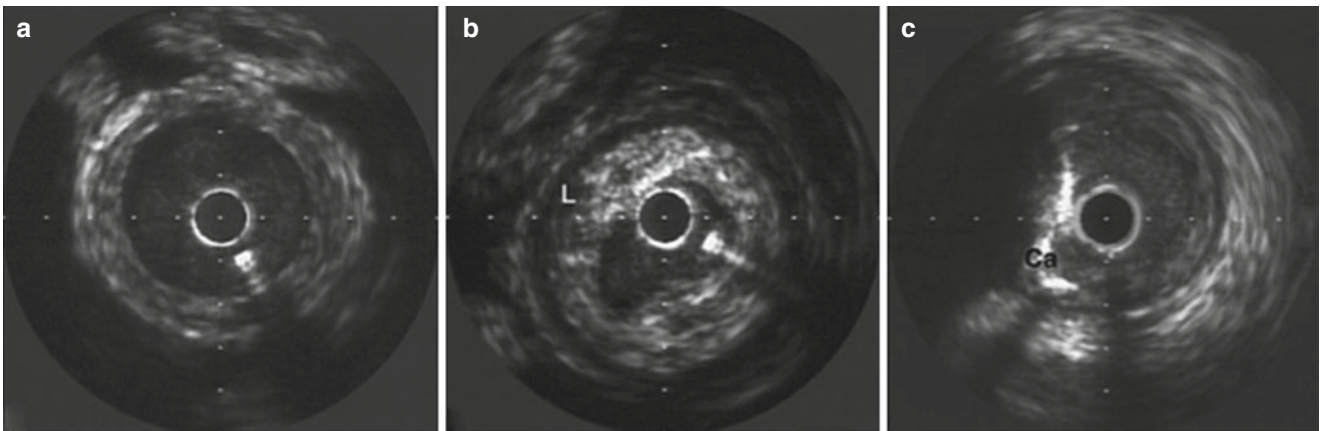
Typical intravascular ultrasound appearances of saphenous (a) vein graft neo-intimal hyperplasia. (b) L–lipid rich plaque. (c) Ca–calcified appearance of atheroma in native vessel. (Adapted from Motwani and Topol [3])
